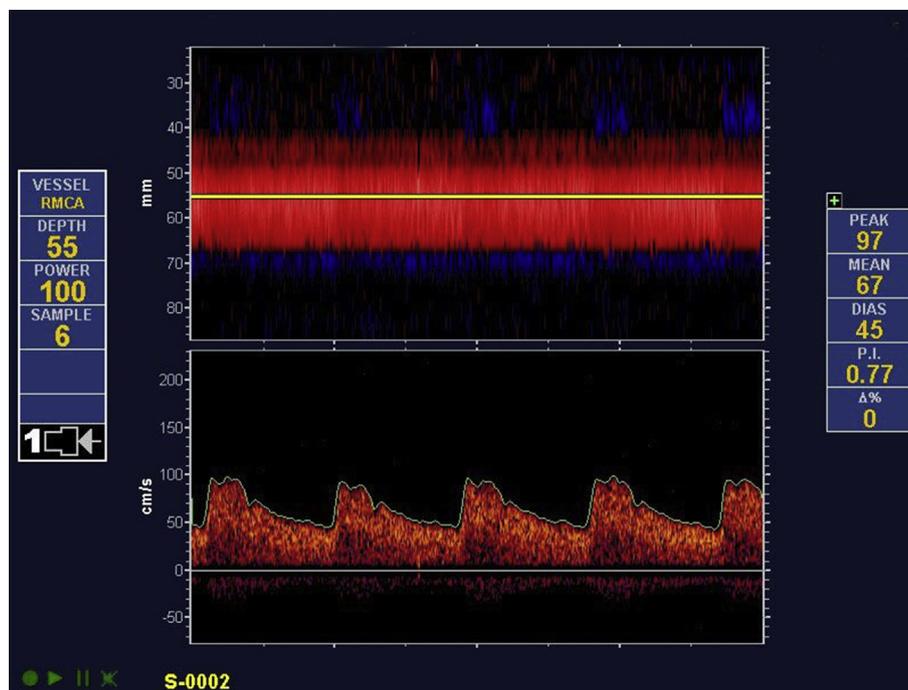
Transcranial Doppler curve and M-mode.
